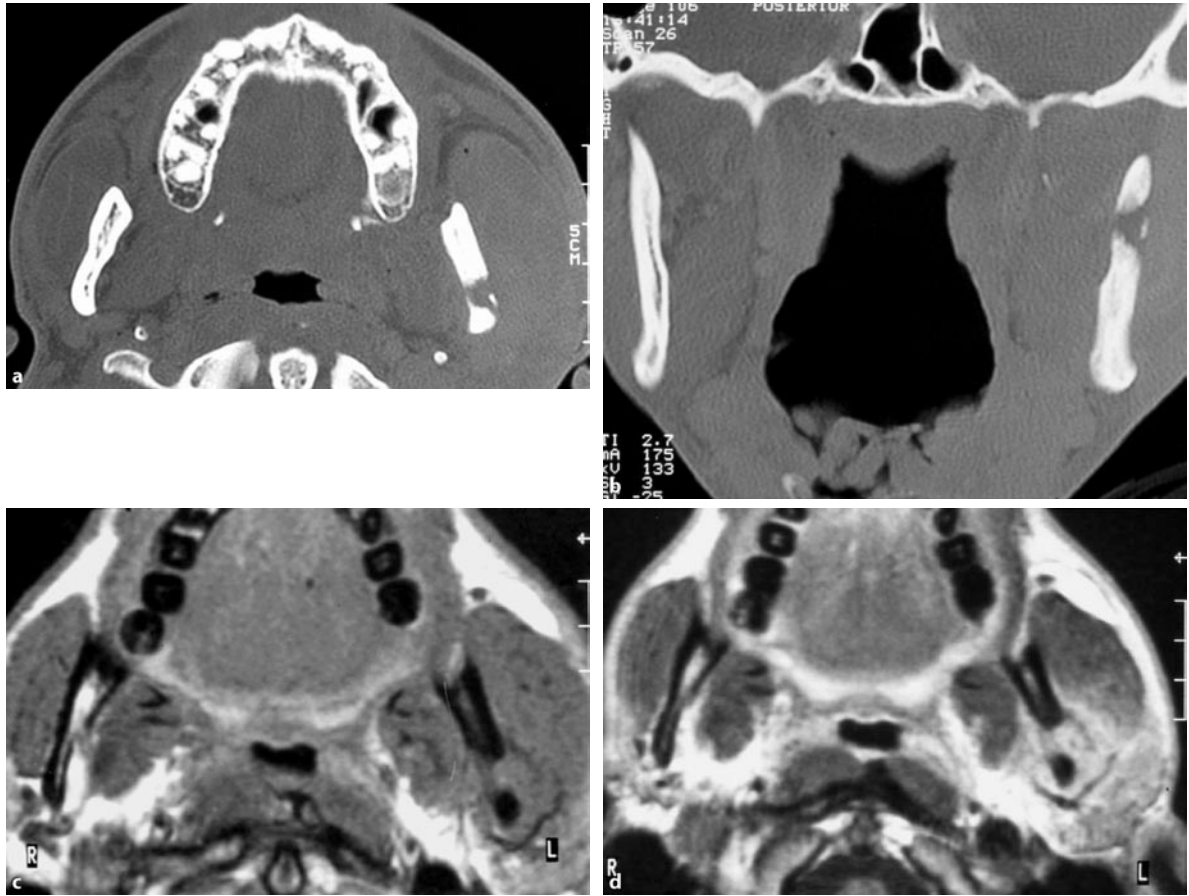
Secondary chronic osteomyelitis: a 25-year-old man 11 months following tooth extraction and conservative treatment of perimandibular abscess. Axial (a) and coronal (b) high-resolution bone-window CT images depict left ascending ramus cancellous bone sclerosis and thickening, localized osteolysis with buccal sequester formation and marked thickening of masseter
